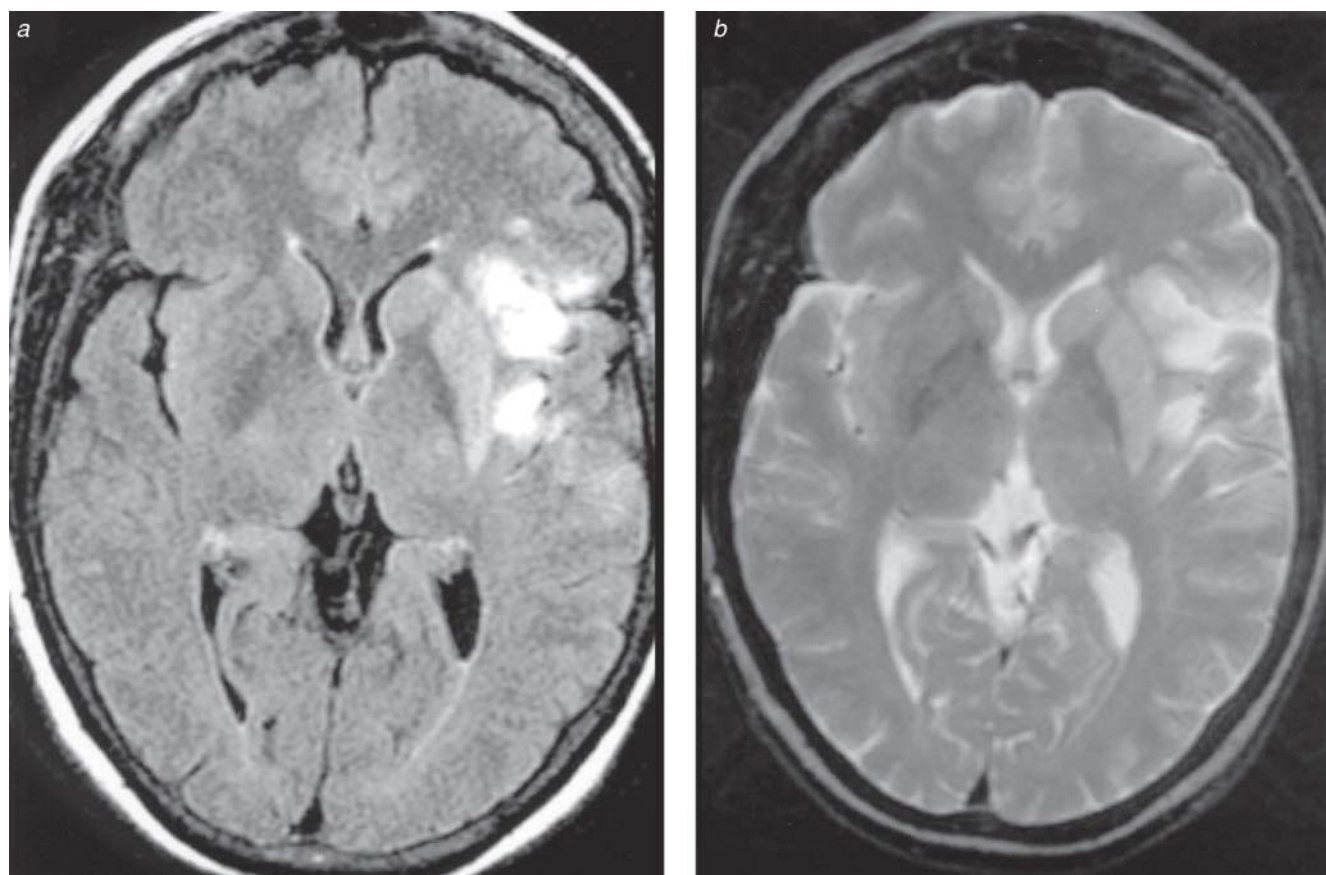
Shown are (a) a fluid-attenuated inversion-recovery (FLAIR) magnetic resonance image (MRI) and (b) a T₂-weighted MRI of an acute ischemic infarct in the left middle cerebral artery distribution.
